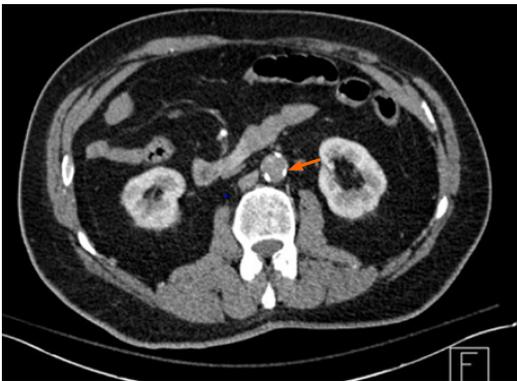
Computed tomography angiogram of the abdomen- shows the abrupt loss of contrast in the aortic lumen indicating the occlusive thrombus that resulted in the patient's symptoms of back pain and loss of lower extremity motor function due to vascular insufficiency. This imaging modality was chosen to visualize the vasculature to evaluate for aortic dissection, aneurysm, or thrombosis given patient's symptoms of crushing back pain with lower extremity motor loss. Aortic calcification incidentally visualized.
